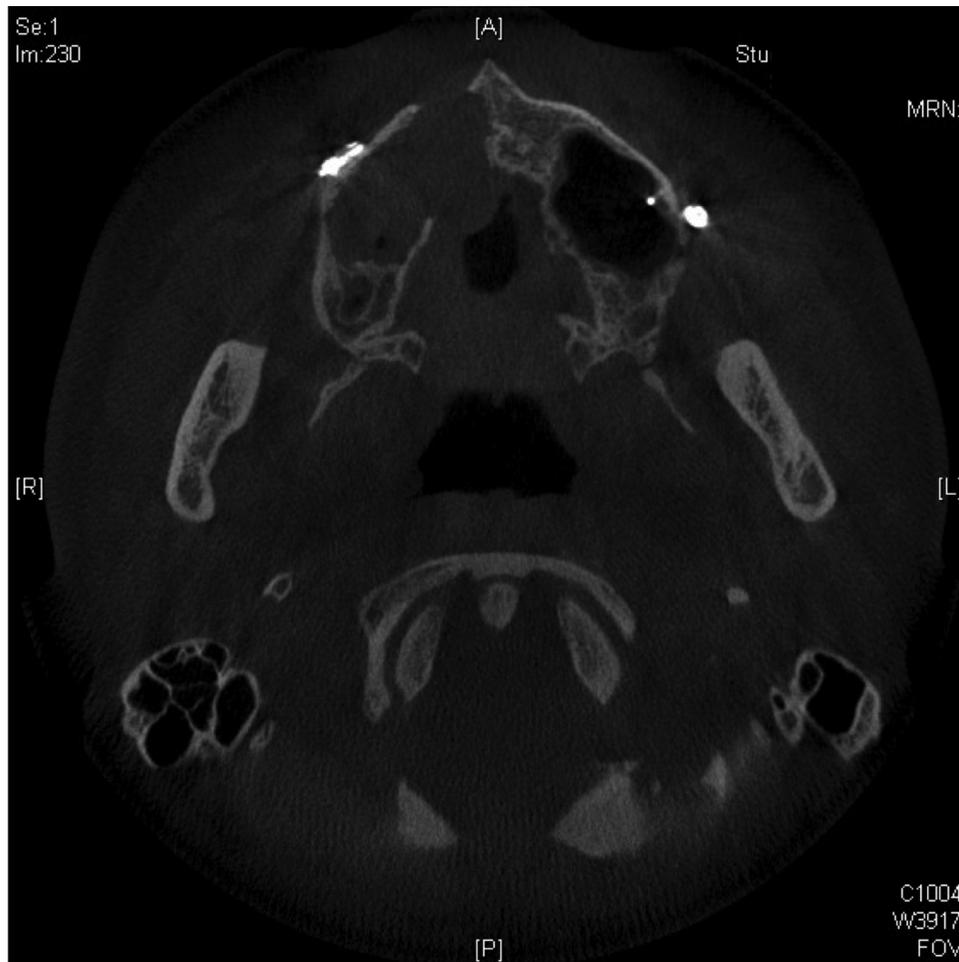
Axial cone-beam computed tomography showing partial bone defect of the labial and palatal side of the maxilla.
